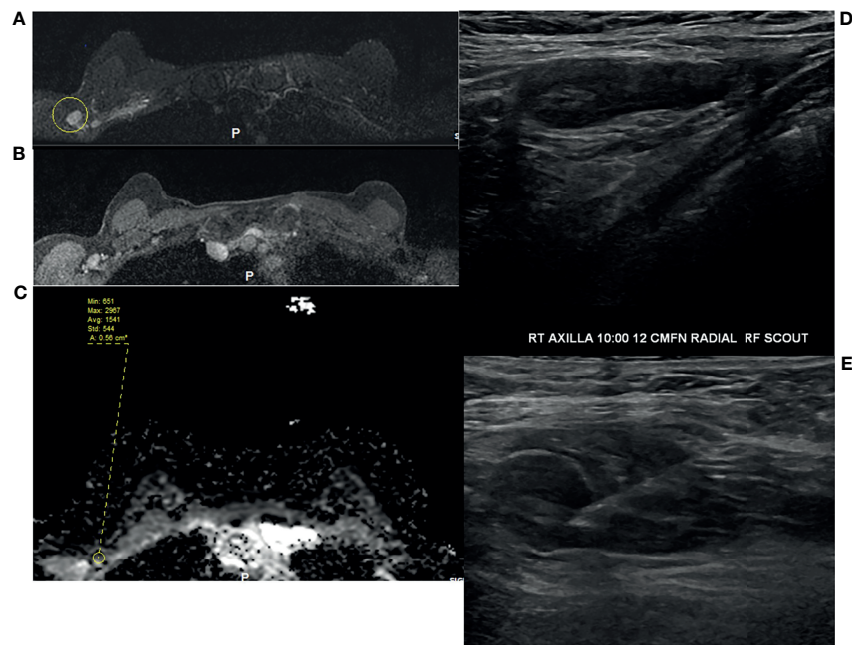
49-year-old woman underwent routine screening breast MRI exam. She received a dose of the COVID vaccine in the right arm a few months prior to her breast MRI. Enlarged right axillary lymph nodes were identified on breast MRI. (A) T2-weighted fat saturated image, (B) T1-weighted fat saturated post-contrast image, and (C) ADC. She subsequently underwent diagnostic ultrasound and ultrasound-guided fine needle aspiration (D, E), which yielded benign results.
